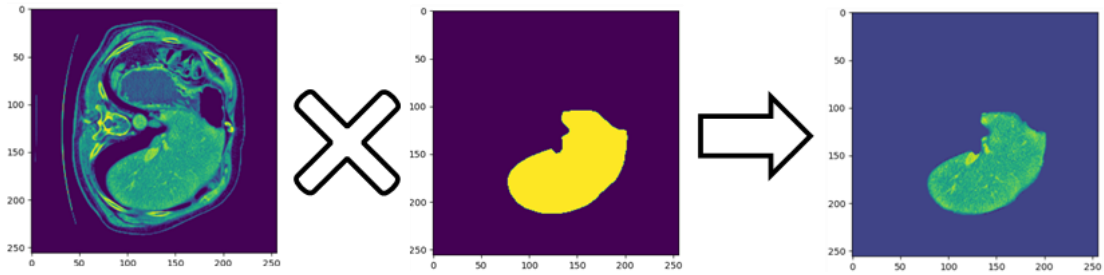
Element-wise multiplication of the CT scan slice with its liver mask.
